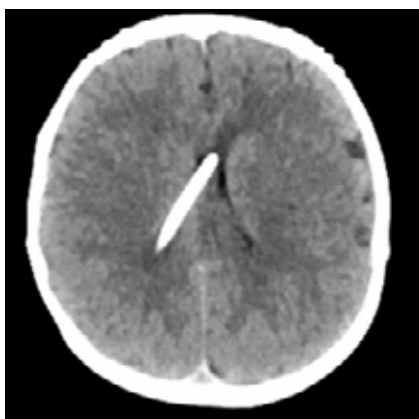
Follow up head CT without contrast at age 4 demonstrated well decompressed ventricles with right occipital ventriculo-peritoneal shunt catheter
